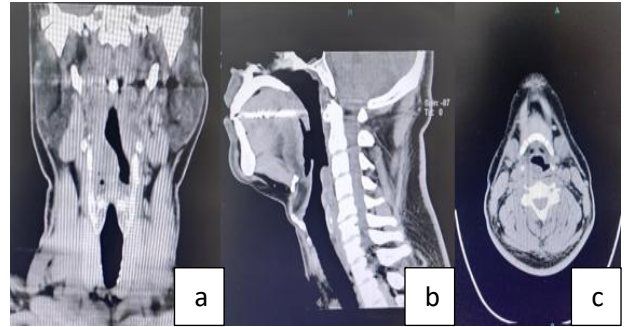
(a-c): CT images (coronal, sagittal and axial) showing the location of the lesion.
